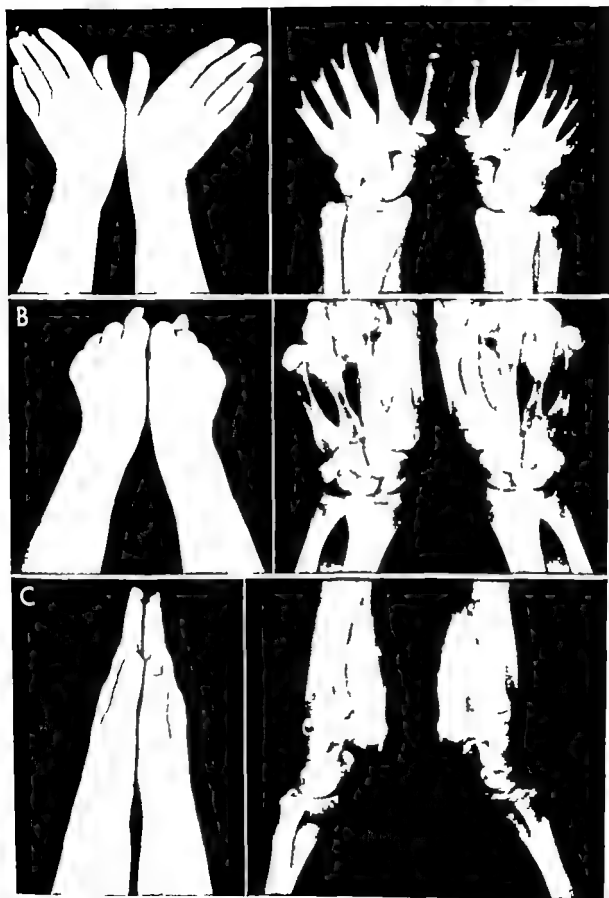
Position of hands for x-ray of carpus with accompanying x ray views A ulnar deviation. B clenched fist C, lateral (continued)
